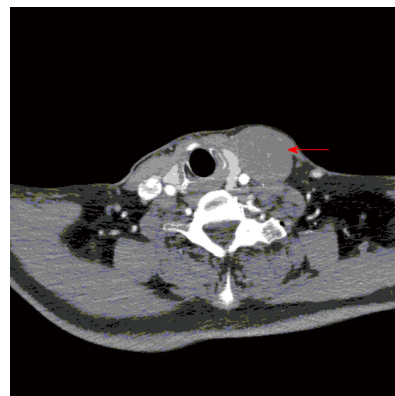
Computed tomography: The mass appeared as a low density cyst with clear edge without contrast enhancement.
